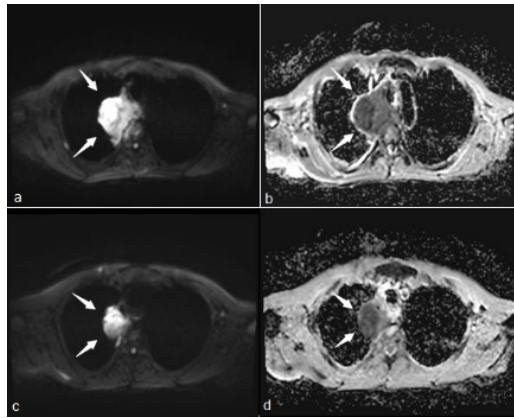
Transverse images in a 60 -year-old-man with squamos cell carcinoma a) pre-chemotherapy Transverse diffusion-weighted echo-planar MRI shows mass at the upper right lobe (arrows). b) pre-chemotherapy ADC map showing that mass is hypointense; ADCmean:0.735x 10⁻³ mm²/sec. c) Post-chemotherapy Transverse diffusion-weighted echo-planar MR image shows decrease of volume of mass at the upper right lobe (regression). d) Post-chemotherapy ADC map; ADCmean:0.655x 10⁻³mm²/sec.
